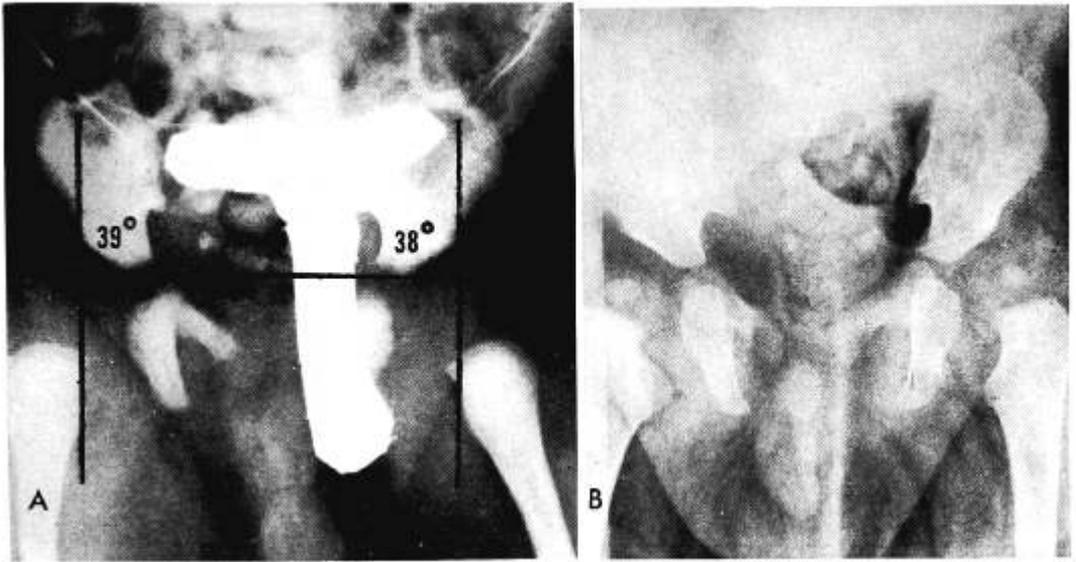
Case 5. This newborn male infant had unstable hips demonstrable at 4 weeks of age. The roentgenogram (A) was taken at age 5 days and shows no convincing abnormalities. The right acetabular index is at the upper limits of normal (39°), but other findings are negated because of a slight amount of pelvic rotation in the film. Treatment was refused. Seven months later a roentgenogram (B) showed definite subluxation of the left hip and residual dysplasia on the right. This boy was hospitalized to assure regular, effective treatment. (C) Result 6 months later.
